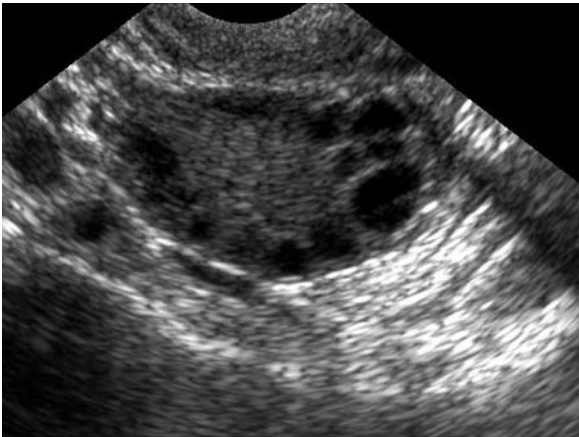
Sonographic aspect of a polycystic ovary.
